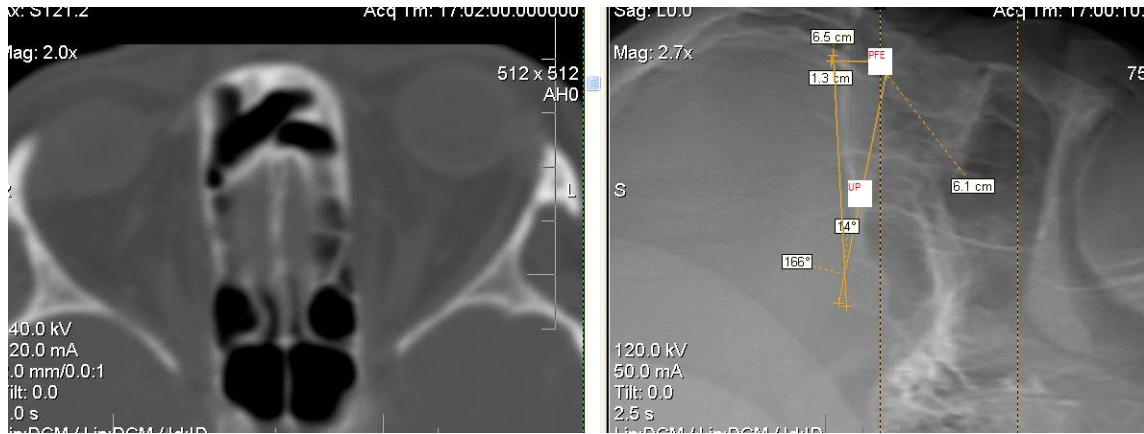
CT craniocerebral exploration UP= 14° and PFE 1.3 cm
